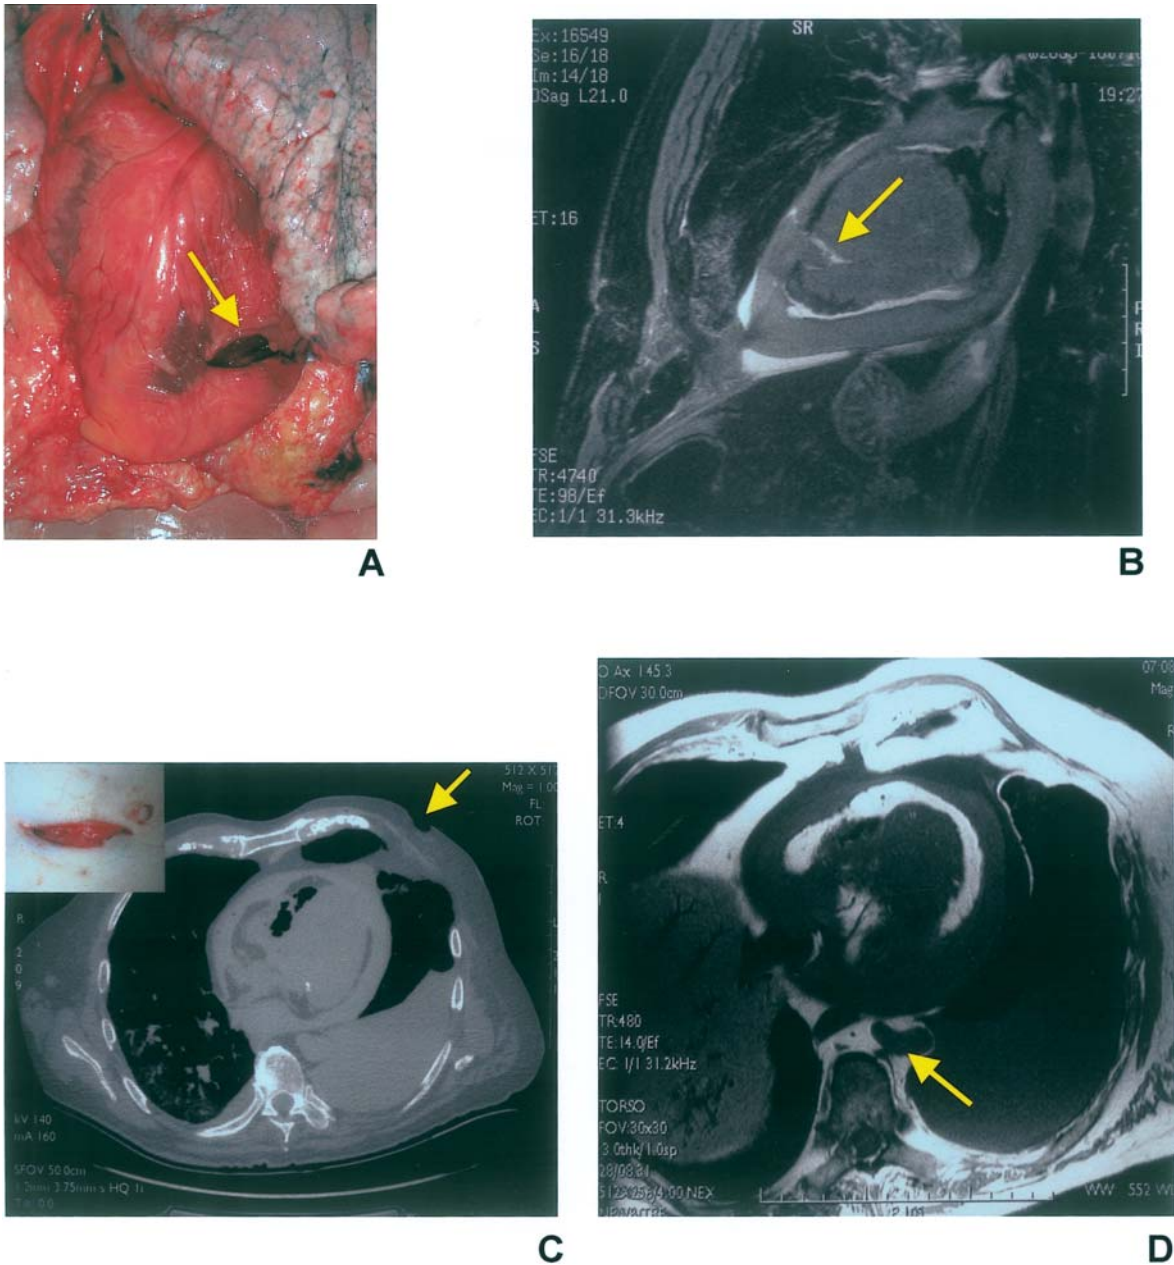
Self-inflicted stab wound to the heart (Case 036): (a) lesion of the ventricle as found during autopsy (arrow); (b) sagittal T2-weighted fast SE MR image (4740/98) showing penetration of the myocardium (arrow) with hemopericardium and intracardial blood clot; (c) skin lesion seen before autopsy (inset) and axial CT scan showing the skin defect (arrow) and the wound canal with hemopericardium, hemothorax, and intracardial air embolism; (d) corresponding axial T1-weighted fast SE MR image (480/14); clotting and hemopericardium are indicate of (short) survival time; the descending aorta (arrow) is collapsed following blood loss (c,d).
